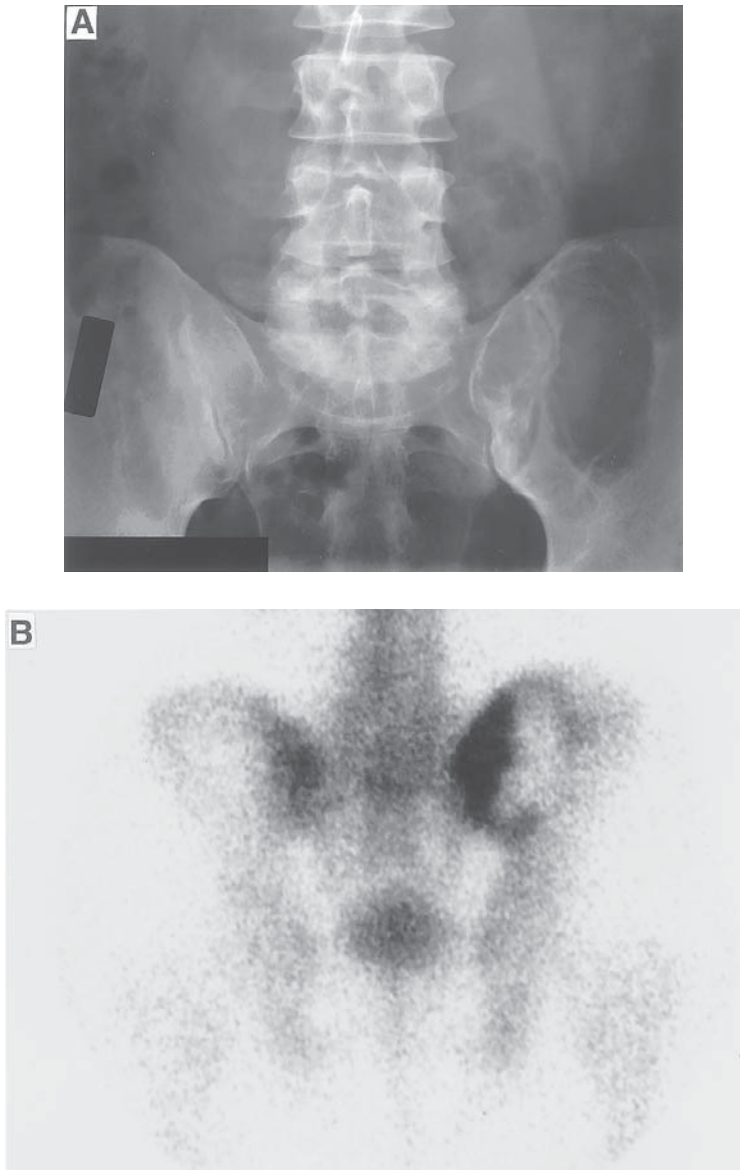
(A) Radiograph of a lytic expansile lesion of the posterior left pelvis in a 39-yr-old male. (B) Bone scan demonstrates a photopenic central area with surrounding increased uptake of radionuclide.
